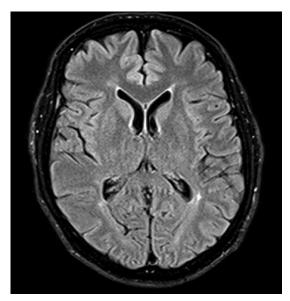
Case 2. MRI scan shows mild cortical atrophy of frontal lobes, and bilateral small size white matter hyperintensities
